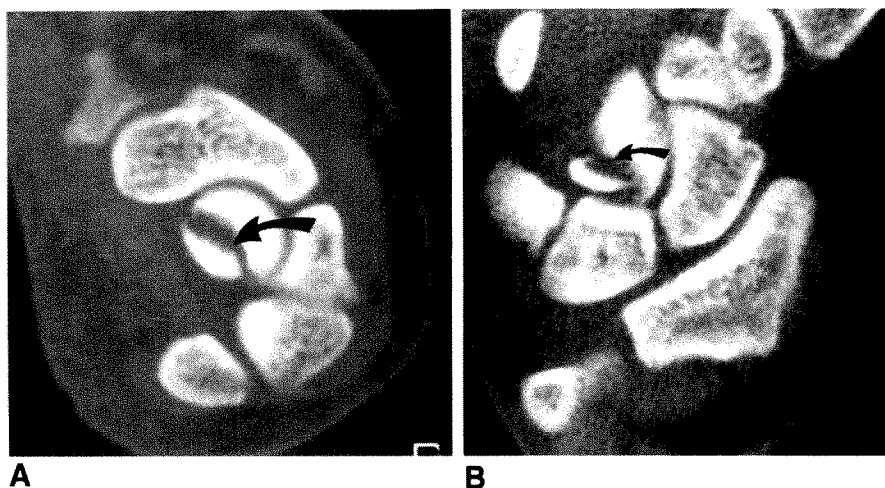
CT can identify underlying process in occult pathologic fractures. All radiographs were normal.
